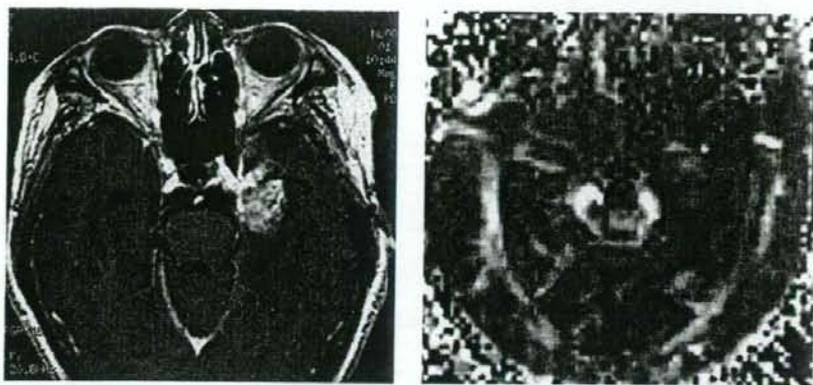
Case 2—images obtained from a 56-year-old woman. Left: T1-weighted magnetic resonance images with gadolinium revealing massive enhanced lesions in the left temporal lobe. Right: co-registered FA maps from DT imaging. The FA value was 0.29 ± 0.04 .
